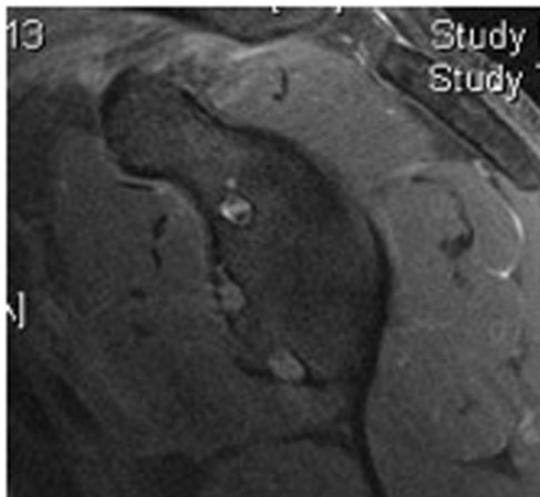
T2-weighted sagittal magnetic resonance imaging sequence of the glenoid showing evidence of three anchors from a previous anterior stabilization and re-tear of the anterior inferior glenohumeral capsule.
